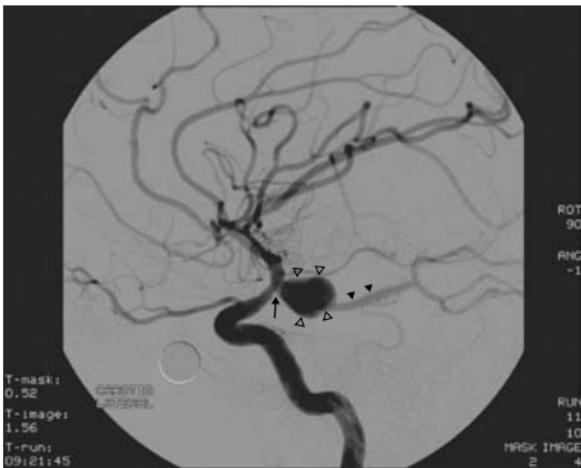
Right posterior communicating artery aneurysm (PCom) and SAH. (a) Axial multiplanar reformation (MPR) from CT angiogram; (b), (c), and (d) digital subtraction angiogram and coil embolization. Ill defined hyperdensity is shown within the right Sylvian fissure proximally (open white arrowheads) in keeping with acute subarachnoid haemorrhage. The fundus of the large PCom artery aneurysm (white arrowheads) is directed posterolaterally and the neck arises from the communicating segment of the right internal carotid artery (white arrows). This is confirmed on digital subtraction angiogram following selective catheterization of the right internal carotid artery. In (b) the aneurysm (open black arrowheads) arises via a relatively narrow neck (black arrow) from the communicating segment of the right ICA. Note contrast within the right posterior cerebral artery (closed black arrowheads) indicating the presence of a prominent persistent posterior communicating artery.
